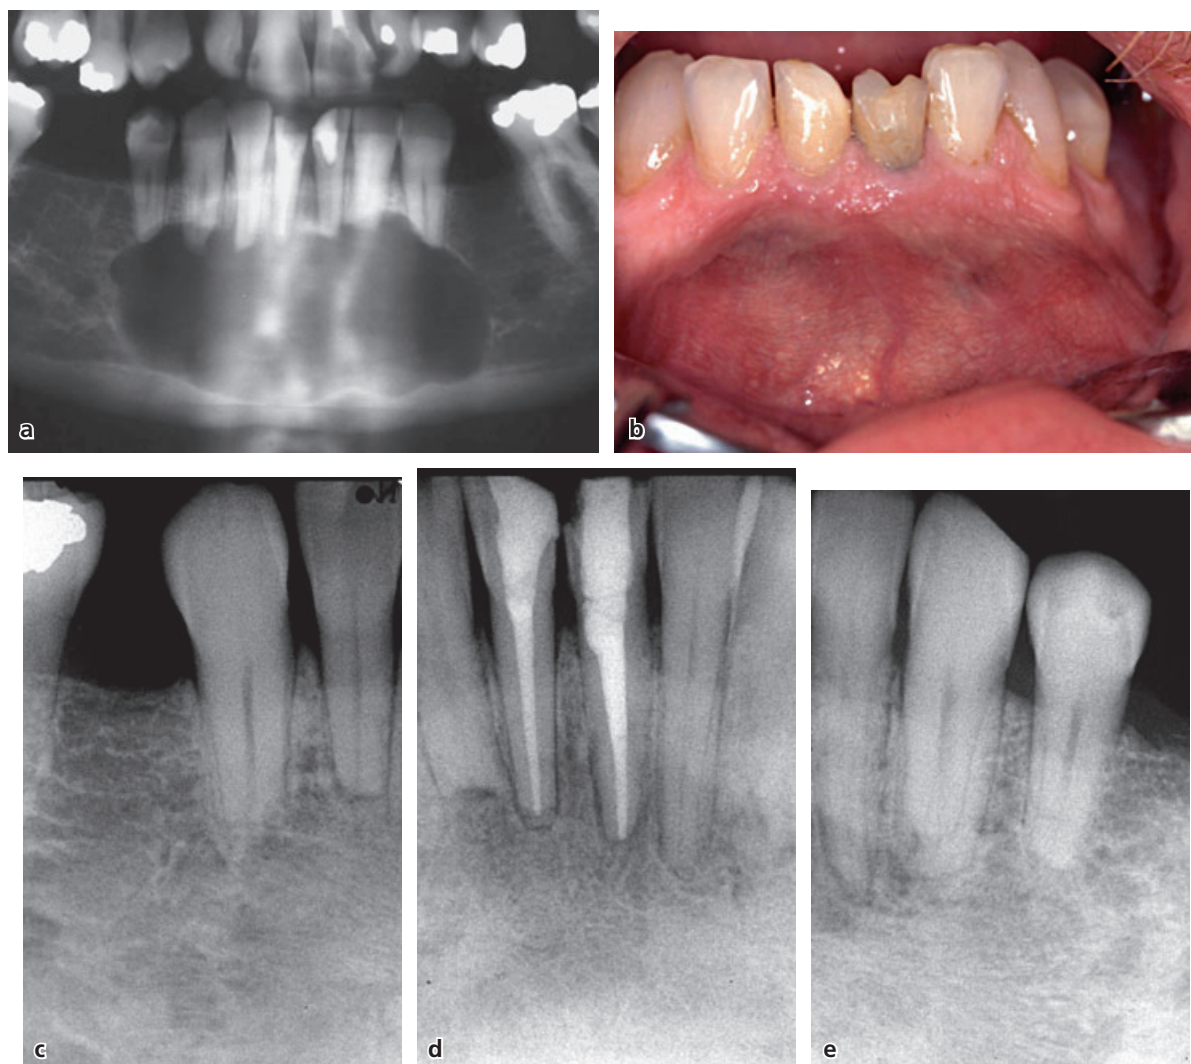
Extensive destruction of alveolar bone as a result of cyst transformation of a periapical lesion emanating from tooth #31. (a) Note root resorption of neighboring teeth. (b) Buccal protrusion of the process was non-painful to palpation. All teeth responded vital to pulp testing except for the root filled teeth #31 and #41. The latter tooth, however, had a vital pulp as revealed on accessing the root canal. Treatment, carried out in collaboration with Dr. Ulf Lekholm, included placement of an obturator for drainage, decompression, and saline irrigation of the cyst cavity over 6 months. Following its reduction, teeth #31 and #41 received completion of endodontic treatment and a residue of the process was excised surgically. (c-e) Complete resolution of the process 10 months post surgery.
